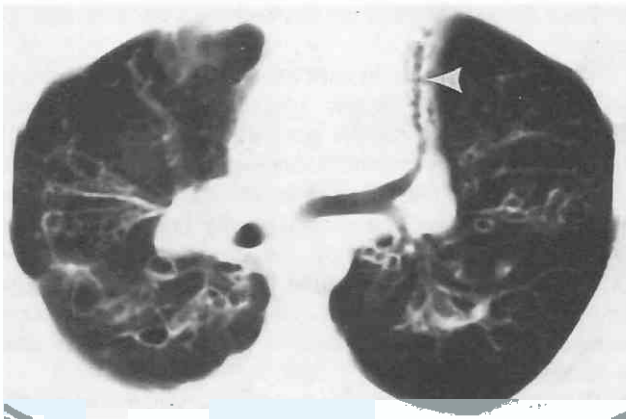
High-resolution CT scan of patient with cystic fibrosis shows multiple sites of bronchiectasis and bronchial wall thickening. There is volume loss within the left upper lobe, demonstrated by medial displacement of the upper lobe bronchus (arrowhead).
